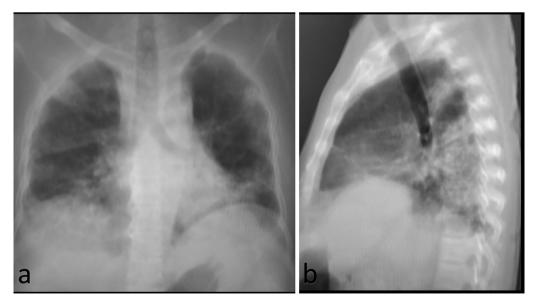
(Chest Radiograph) AP (a) and Lateral (b) views show patchy areas of consolidation in both lobes with lower zone predominance
